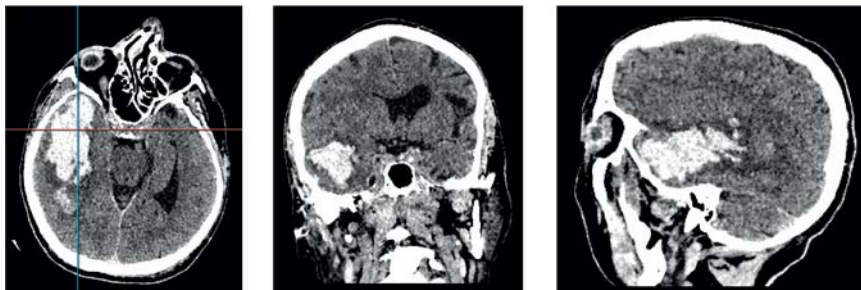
Brain computed tomography scan of patient R., 47 years old, on admission at the hospital
